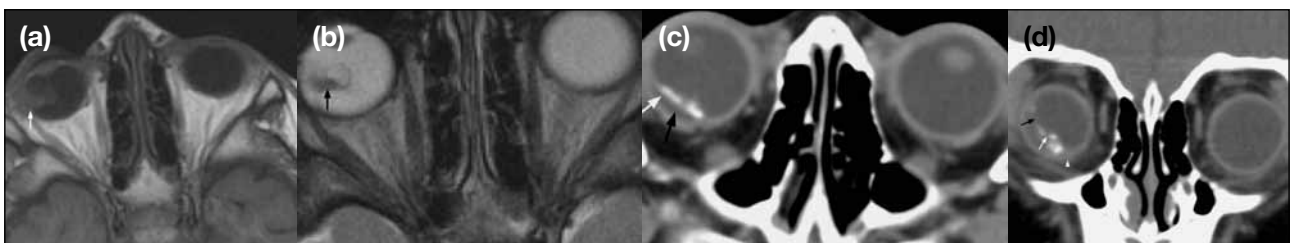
A 3-year-old boy with acute lymphoid leukaemia, who was incidentally found to have a right intraocular mass. Magnetic resonance imaging orbit: (a) T1-weighted and (b) T2-weighted axial images showing partial right retinal detachment with focal thickening at the lateral aspect which is T1 iso- to hyper-intense (white arrow) and T2 hypointense (black arrow). Computed tomographic orbit images: (c) axial image and (d) coronal image revealing calcified leaf (white arrow) of retina present within the right globe (white arrowhead), mimicking retinoblastoma. Subretinal fluid (black arrow) is present posterior to the enhancement. No mass-like enhancement is evident. The right globe is smaller than the contralateral one, and more easily appreciated on coronal imaging.
